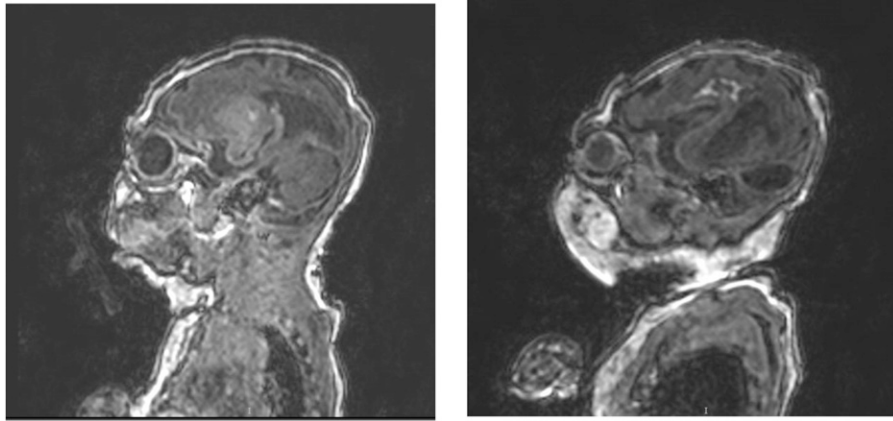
Postnatal magnetic resonance imaging scan showing microcephaly, pachygyria, partial agenesis of the corpus callosum, ventriculomegaly, vermian hypoplasia, and parenchymal calcifications.
